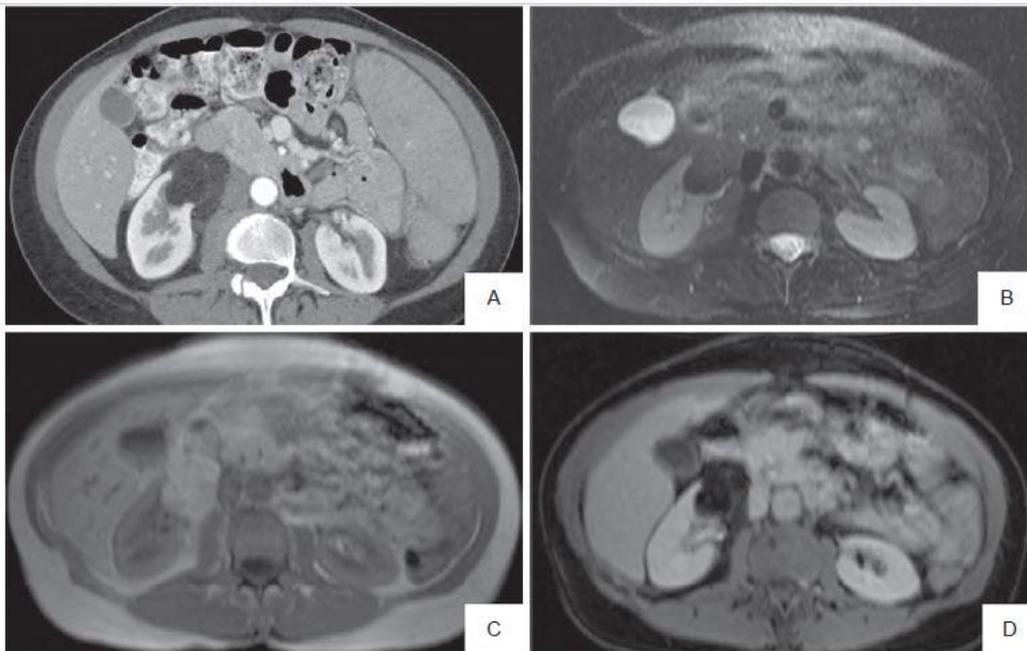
(A) Contrast-enhanced computed tomography demonstrating macroscopic intralésional fat. (B) T2-weighted magnetic resonance imaging (MRI) with hypointensity. (C) Non-contrast-enhanced T1 MRI with hyperintensity of lesion secondary to macroscopic fat. (D) Post-contrast, fat-suppressed T1 image with signal dropout of mainly fat containing lesion, all consistent with classic angiomyolipoma. (From Flum AS, Hamoui N, Said MA, et al.: Update on the diagnosis and management of renal angiomyolipoma. *J Urol* 195[4 Pt 1]:834–846, 2016.)
